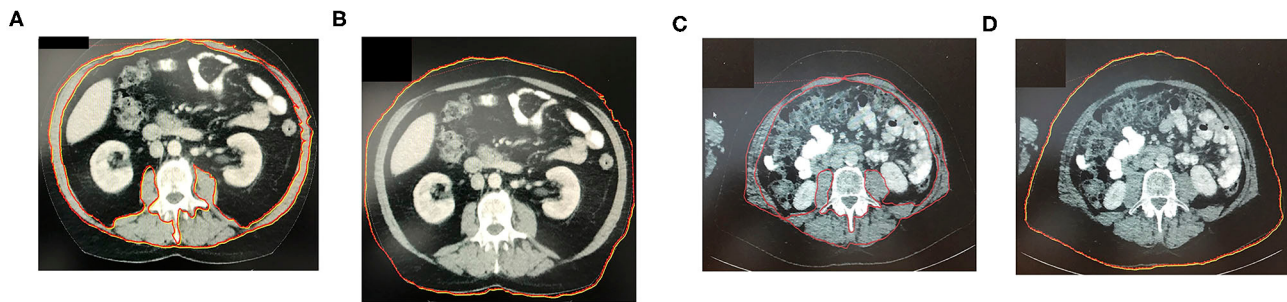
(A,B) Axial CT-image at L3 vertebra depicting patient without sarcopenia. (C,D) Axial CT-image at L3 vertebra depicting patient with BMI and significantly different SMI (sarcopenic patient). The red marked area represents the cross-sectional area of all skeletal muscle at L3 including the rectus abdominus; internal, external, and lateral obliques; psoas; quadratus lumborum; and erector spinae muscles. The red marked line in the image represents patients abdominal circumference.
